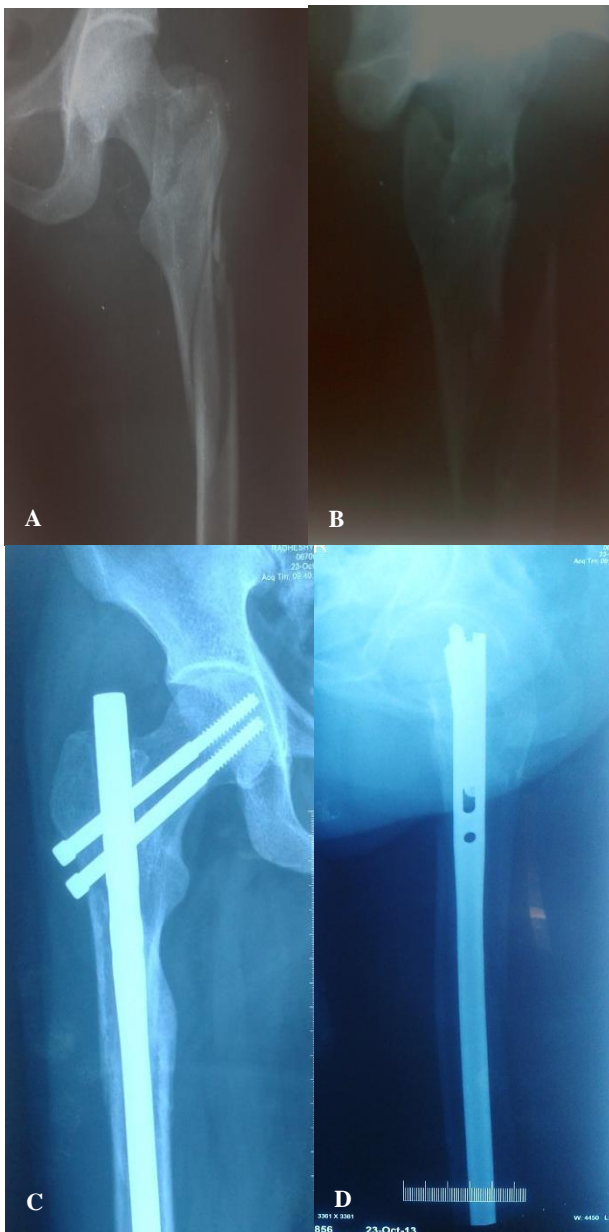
Pre-operative X-rays (A and B) and final follow up with union (C and D).
